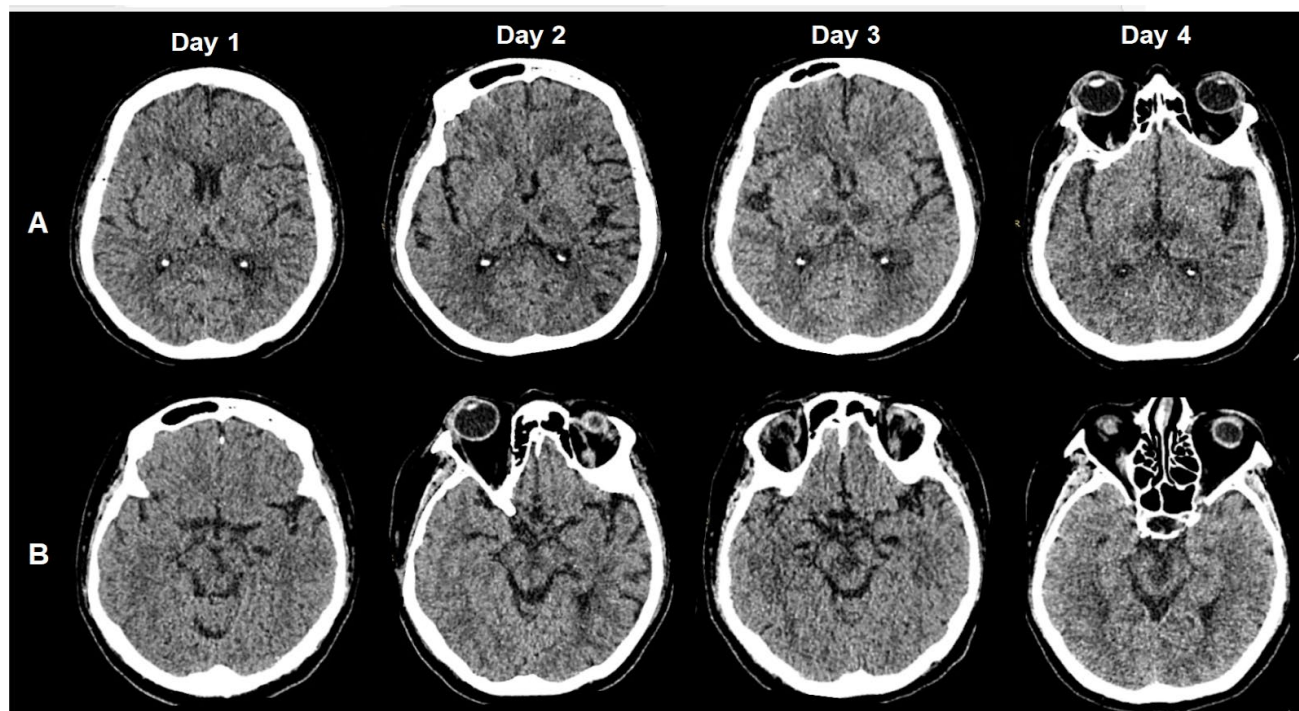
Shows the temporal evolution of a posterior circulation infarction on serial CT brain images at the level of thalami (row A) and midbrain (row B) from day 1 till 4 of hospitalisation.
